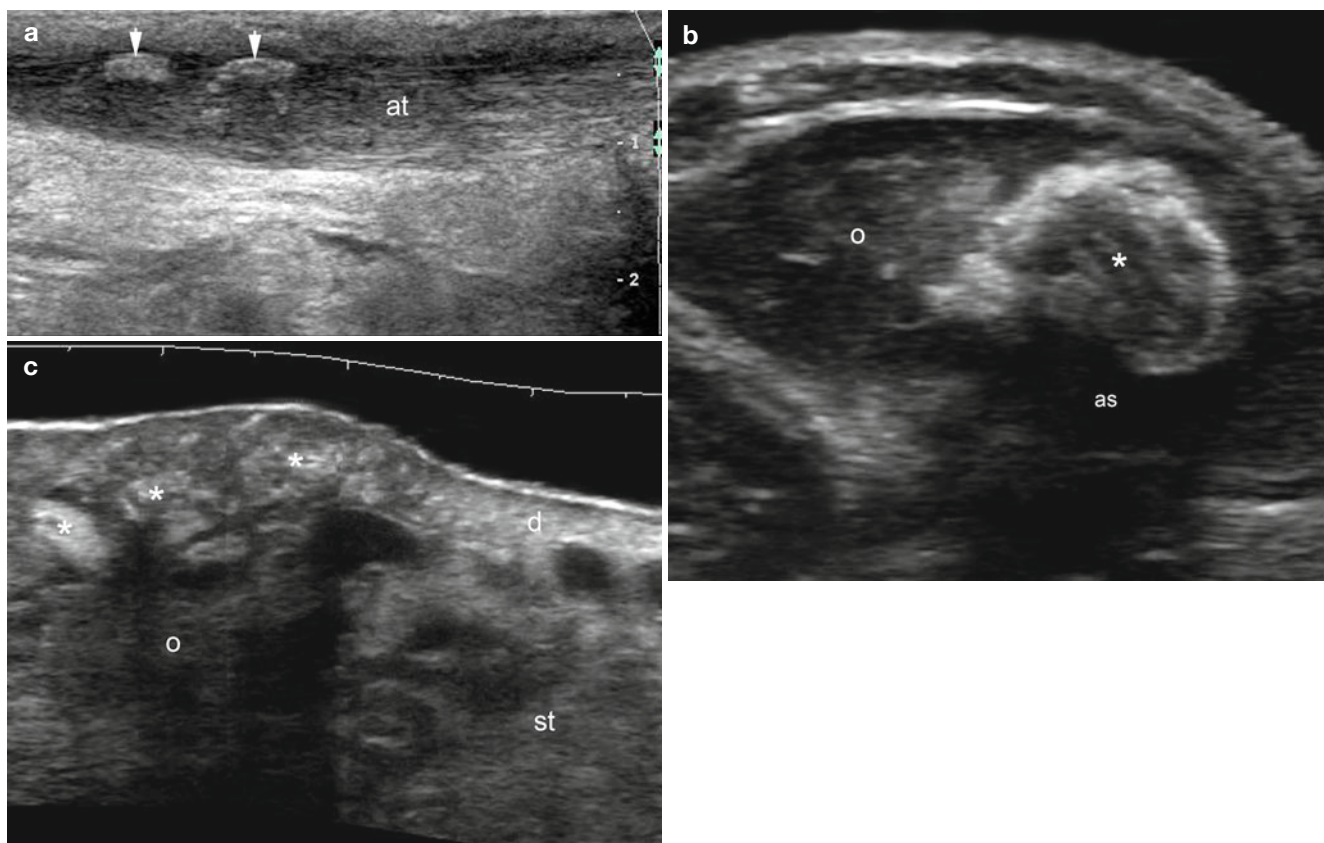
(a–c) Heterotopic ossification. (a) Grey scale ultrasound image (longitudinal view, posterior aspect of the left ankle) demonstrates hyperechoic calcium deposits (*arrows*) within the Achilles tendon (*at*). Thickening and hypoechogenicity of the tendon are also detected (i.e., tendinosis and/or enthesopathy). (b) Grey scale ultrasound image (transverse view; lateral aspect of the left knee) shows a large hyperechoic calcium deposit within a fluid collection. The hyperechoic
